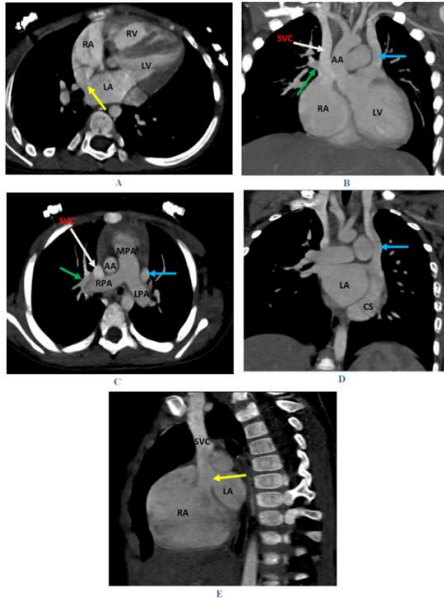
CT cardiac findings
